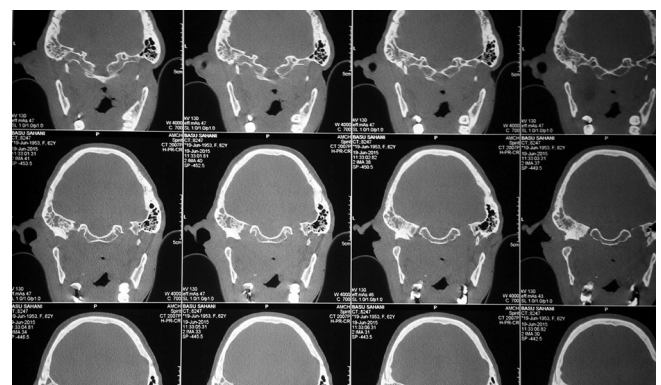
CT Scan of head and neck
